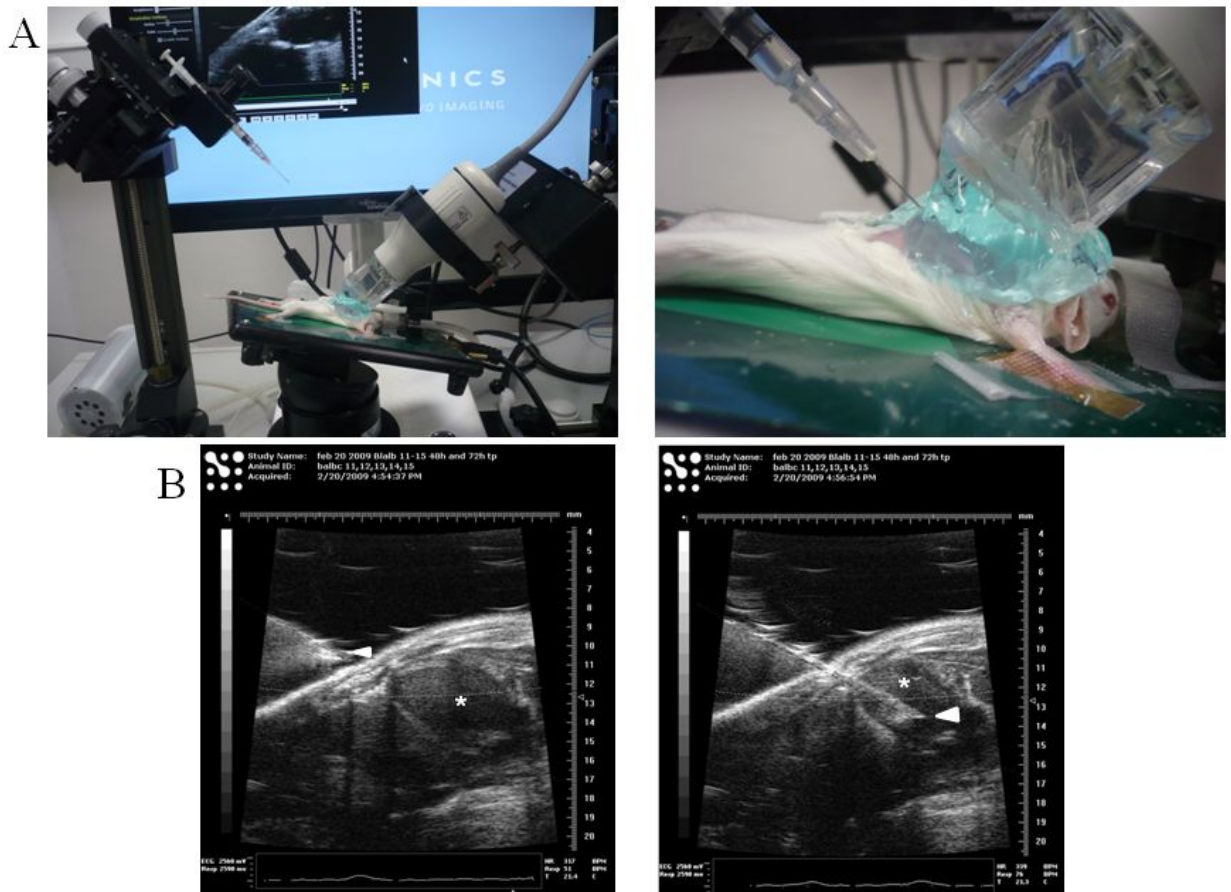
Ultrasound mediated intracardiac injections.
